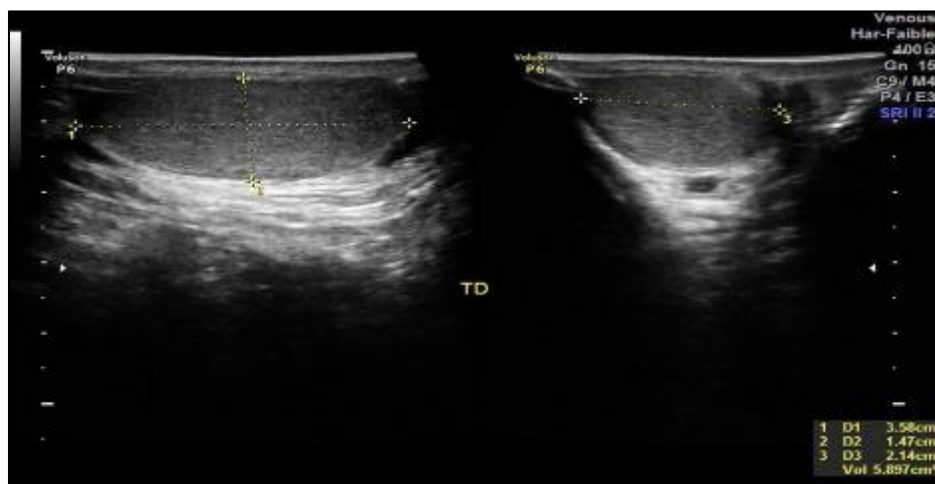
Ultrasound image of the right testicle with a volume of 5.89 cm²
